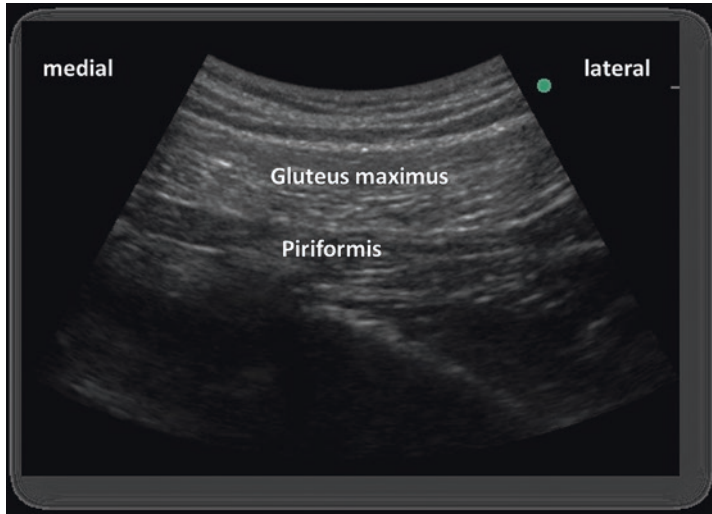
Ultrasound image of structure cephalad to ischial spine level
